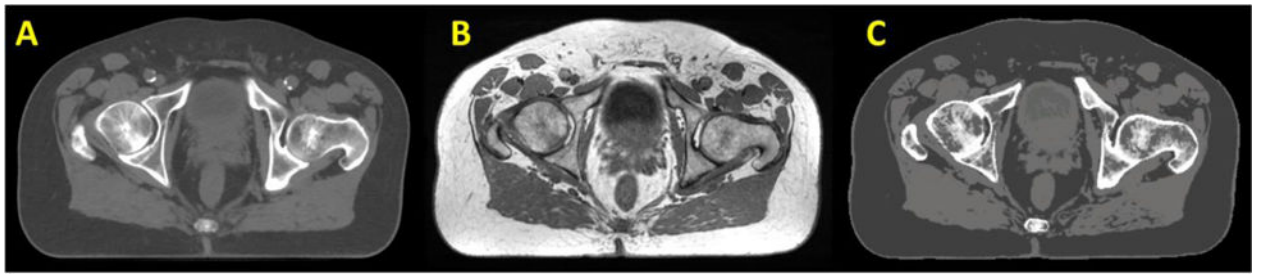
Transverse view of CT (A), MRI (B) and synthetic CT (C) of a patient's pelvis.
